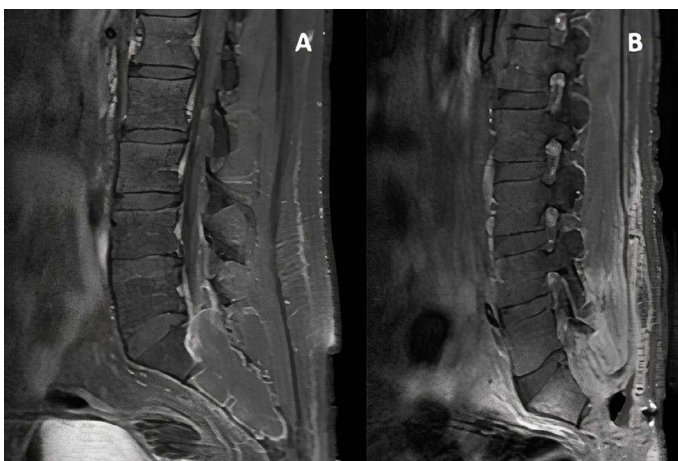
Representative case 2. A: Presurgery MRI showing a solid tumour in sacrum and coccyx enhanced by gadolinium administration. B: Postsurgical MRI showing no evidence of residual tumour
